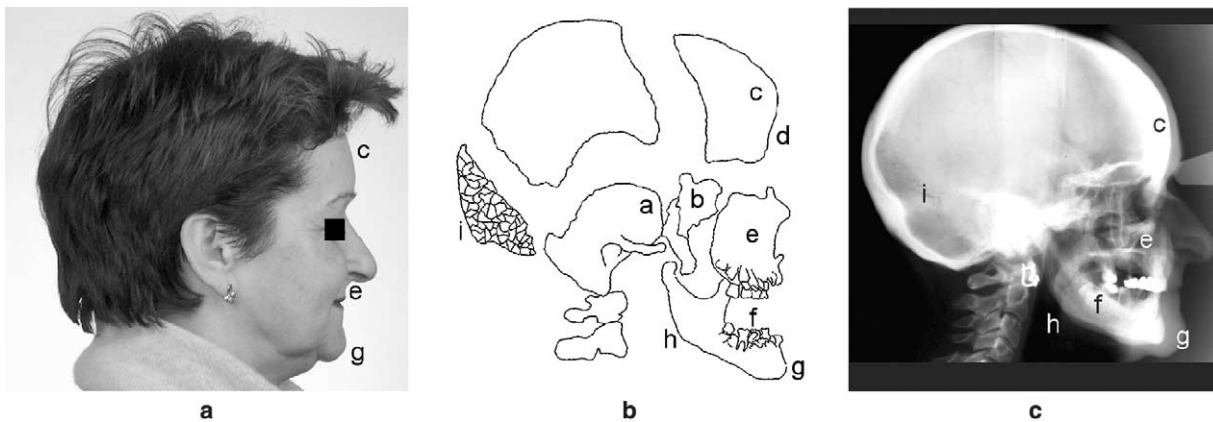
Dentomaxillofacial characteristics of cleidocranial dysplasia, with the first description in the literature: a, deformation of the temporal squama⁷⁶; b, kyphotic spheno-occipital synchondrosis⁷⁶; c, frontal bossing⁷⁵; d, metropic fontanel⁷⁶; e, midface hypoplasia⁷⁵; f, supernumerary teeth⁷⁷; g, prognatic mandible⁷⁵; h, missing gonion angle⁷⁴; i, multiple Wormian bones (Worms, 1643; cited after⁷⁸). (a) Facial morphology in a 50-year-old female; (b) exploded view of the skull; (c) cephalometric radiograph
